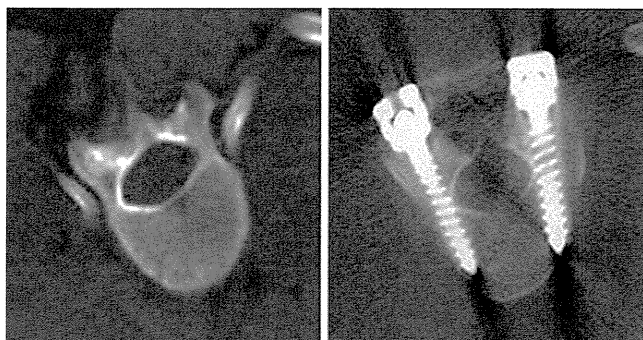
A preoperative CT scan (left) showing a severely rotated T-10 vertebra with narrowed pedicles. A postoperative CT (right) demonstrating 5.5 × 35-mm TPSs placed into the pedicles. These TPSs were in an intrapedicular position.
